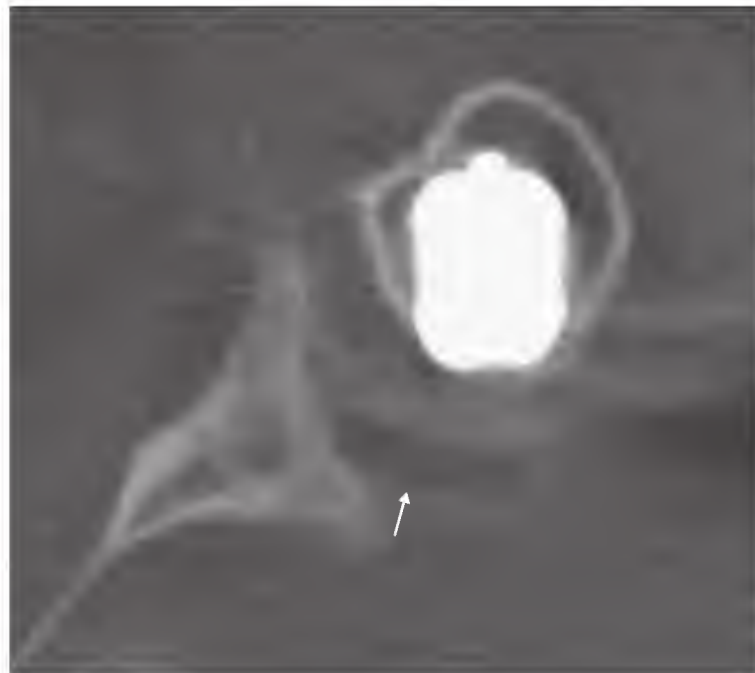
Computed tomographic arthrogram of a total shoulder replacement. Intraarticular contrast medium surrounds the dislocated polyethylene glenoid component (arrow).
